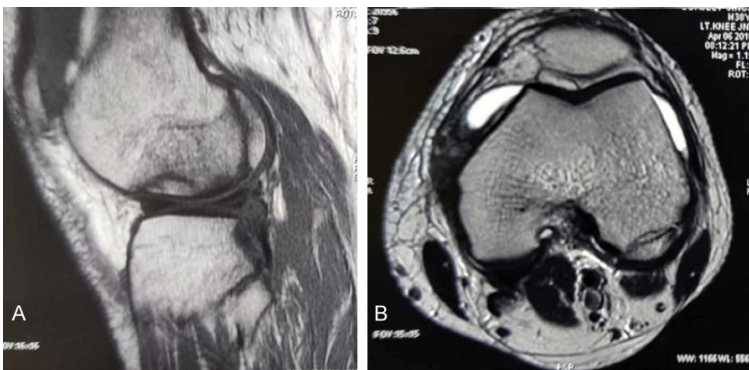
MRI showing no signs of avascular necrosis of the fracture fragment.
